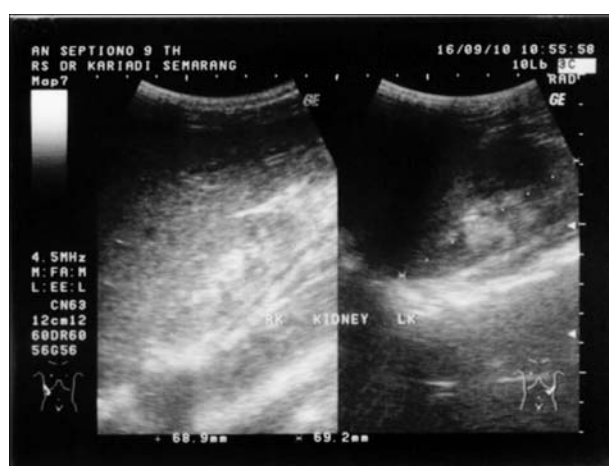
Ultrasound of kidneys showing small size, loss of corticomedullary differentiation and increased echogenicity
